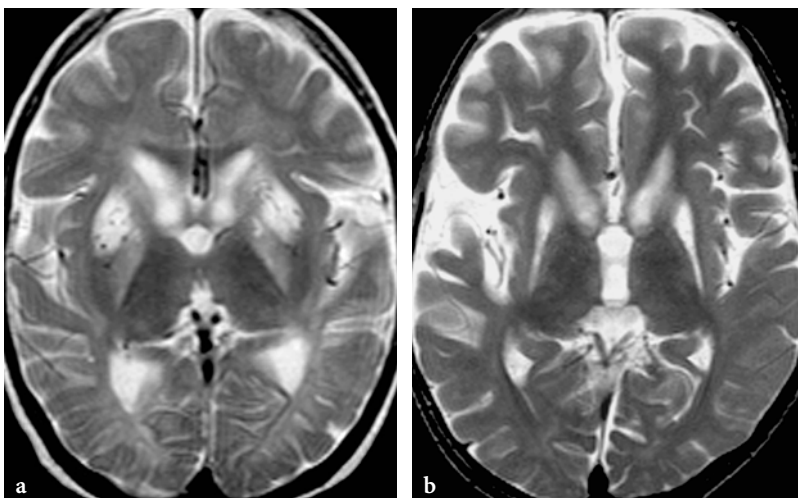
Bilateral basal ganglia lesions in acute, subacute, and chronic stages of 3-methylglutaconic aciduria on axial T2-weighted fast spin-echo images. a 1-year-old female patient with 3-methylglutaconic aciduria during acute metabolic decompensation. Signal abnormalities are seen within the globi pallidi, heads of the caudate nuclei and within the anterior parts of the putamina. The putaminal lesions are associated with swelling. b 10-year-old male patient after several metabolic crises. The putamina exhibit prominent atrophy and marked hypersignal, consistent with necrosis. The caudate nuclei and globi pallidi are also abnormal, but signal and volume changes are less marked on this image
